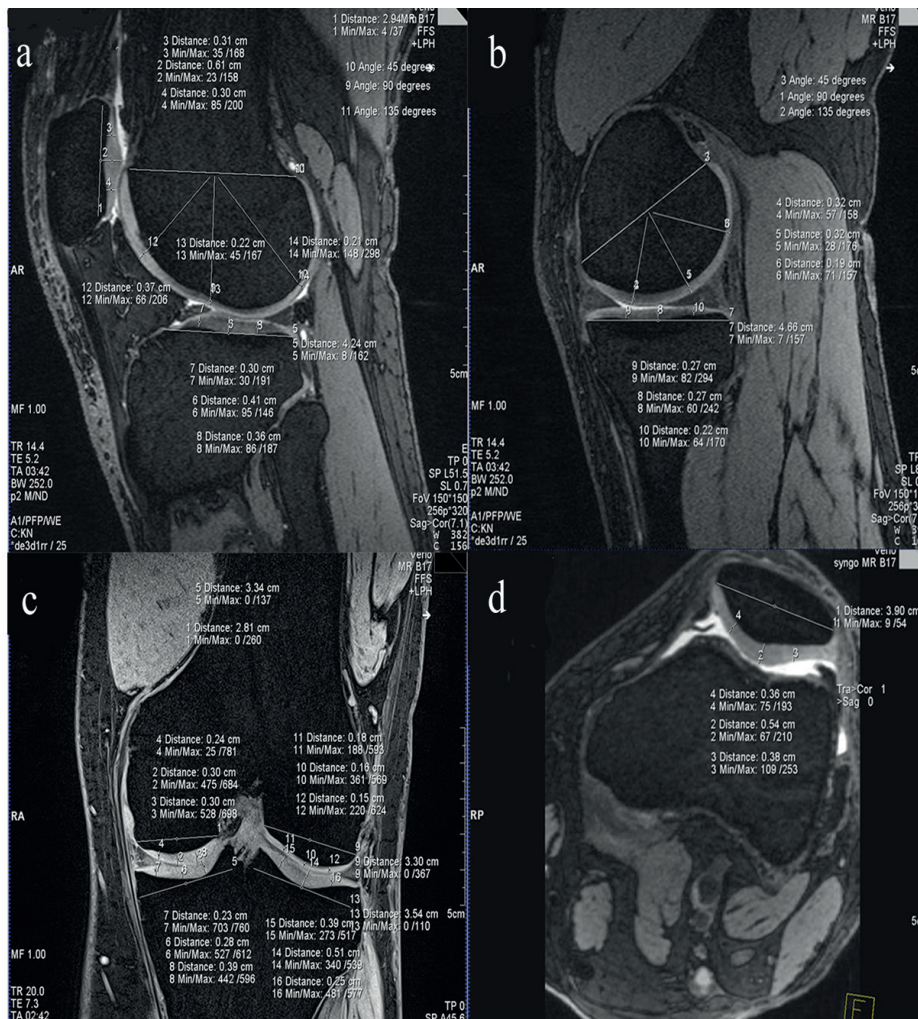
A, A sagittal section shows the cartilage thickness of lateral femur, lateral tibia and patellar. B, A sagittal section shows the cartilage thickness of media femur and medial tibia from. C, A coronal section shows the cartilage thickness of femur and tibia. D, A representative axial cut of a knee MR image shows the cartilage thickness of patellar.
